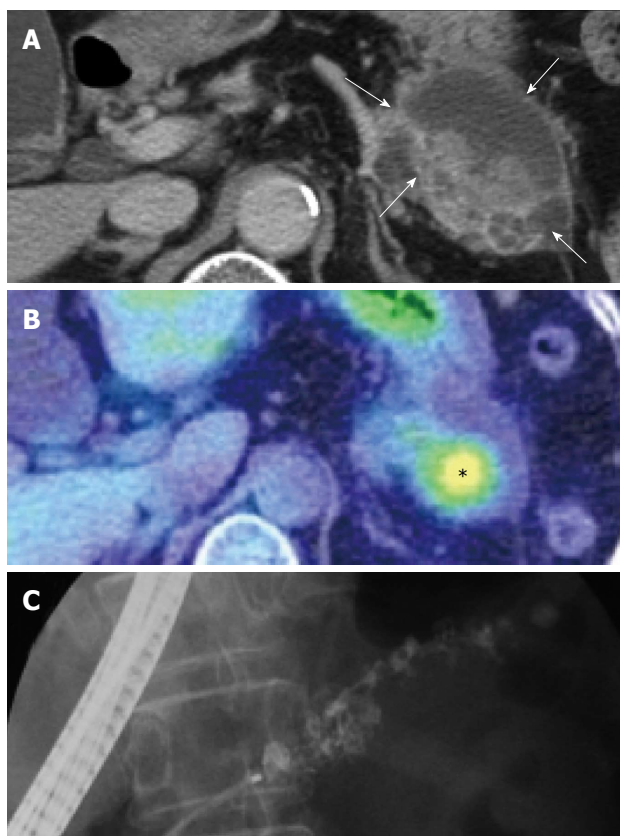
Diagnostic imaging before the first operation. A: Computed tomography showed a low density area (approximately 6 cm) in the pancreas tail (arrow); B: Positron emission tomography-computed tomography showed abnormal uptake of fluorodeoxy glucose (asterisk) in the low density area observed on computed tomography; C: Endoscopic retrograde cholangiopancreatography showed irregular dilatation of the main pancreatic duct in the body and tail.
